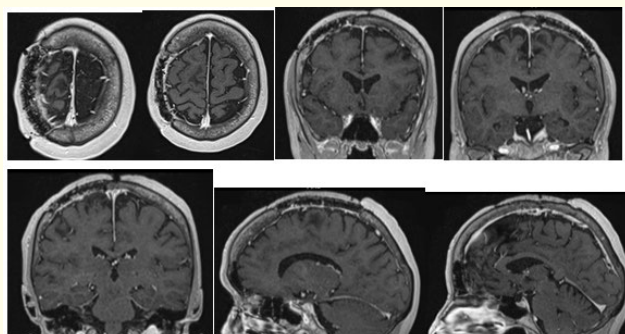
Postsurgical control MRI demonstrating complete excision.
